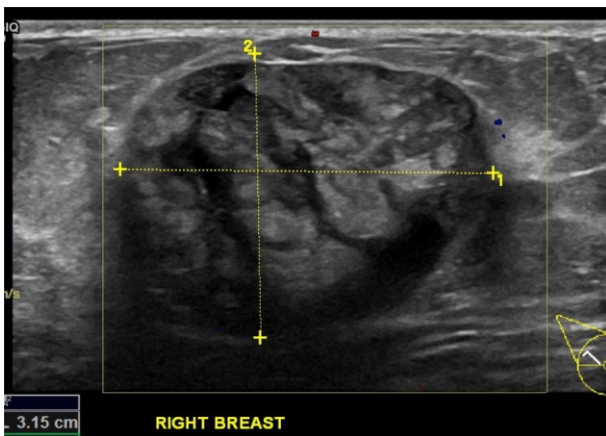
Ultrasound demonstrates a solid 4.25 x 3.3 x 2.4 cm well-circumscribed lobulated mass with a heterogeneous mixed echopattern and, casting a posterior shadow.
